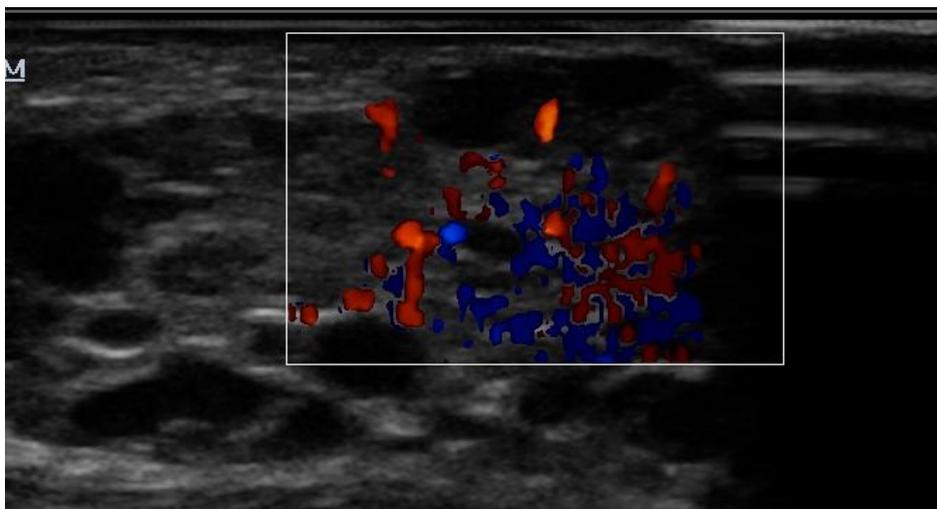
On colour Doppler interrogation, the hypoechoic areas within the right breast shows mildly increased vascularity.
